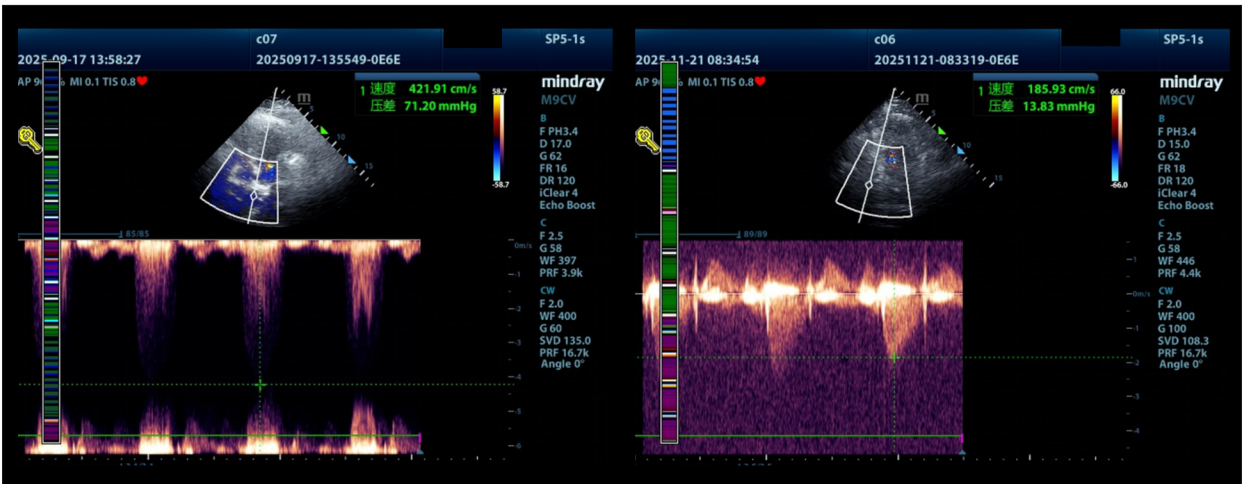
Echocardiographic assessment before and after transcatheter aortic valve replacement. Preoperative assessment on the left image (mean gradient: 71 mm Hg). Postoperative assessment on the right image (mean gradient: 13.8 mm Hg).
